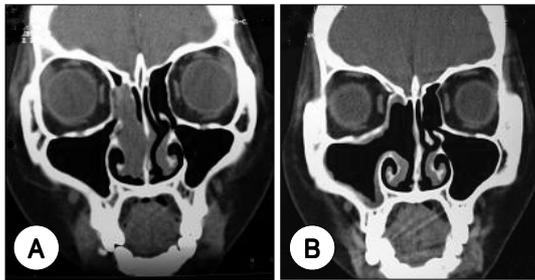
CT images of case 7. Preoperative coronal CT image (A) shows mass filling right nasal cavity with abutting lamina papyracea and invading middle turbinate and ethmoid sinus. There is no evidence of residual or recurrent tumor on follow up coronal CT image (B) after 50 months.
